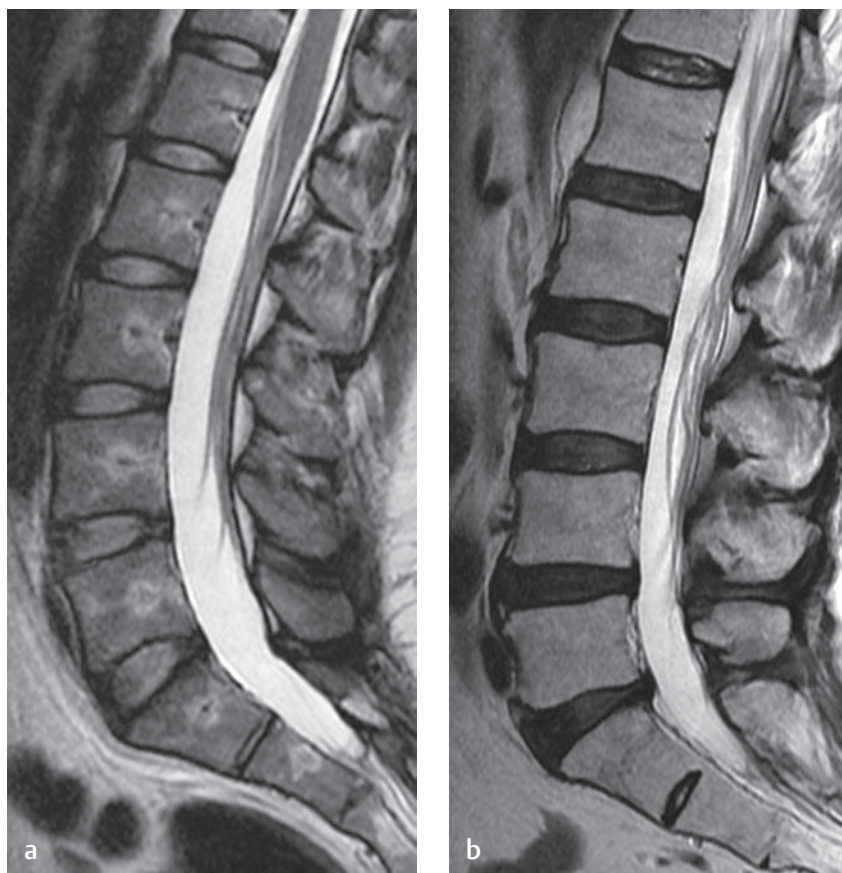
Normal versus desiccated discs. (a) A sagittal T2-weighted image shows bright signal within the lumbar disc corresponding to normal disc morphology and hydration at each level in the lumbar spine. (b) In another patient, the lack of bright T2-weighted signal within the nucleus pulposus in this sagittal view is compatible with disc desiccation. Disc desiccation can be seen in asymptomatic patients as a component of degenerative disc disease.
